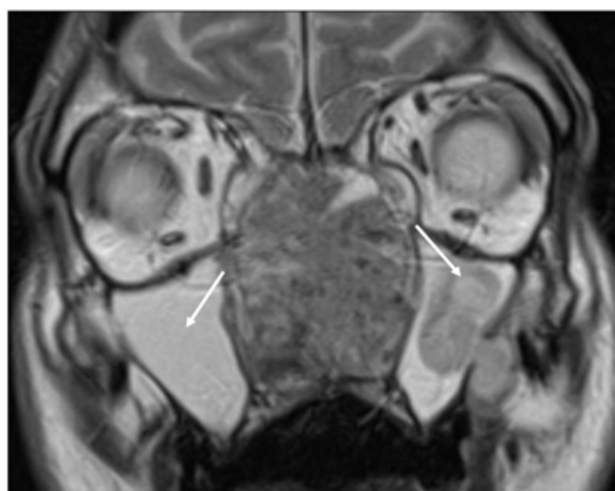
Coronal MRI images showing bilateral retention maxillary sinusitis (white arrows).
